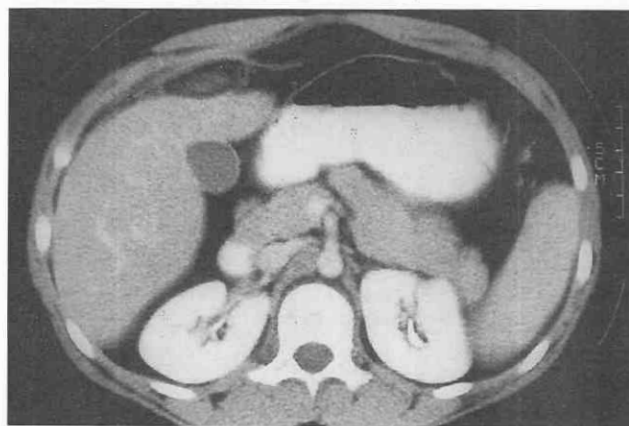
Segmental omental infarction. CT scan through the upper abdomen demonstrates well-circumscribed, focal infiltration of right-sided omental fat.
